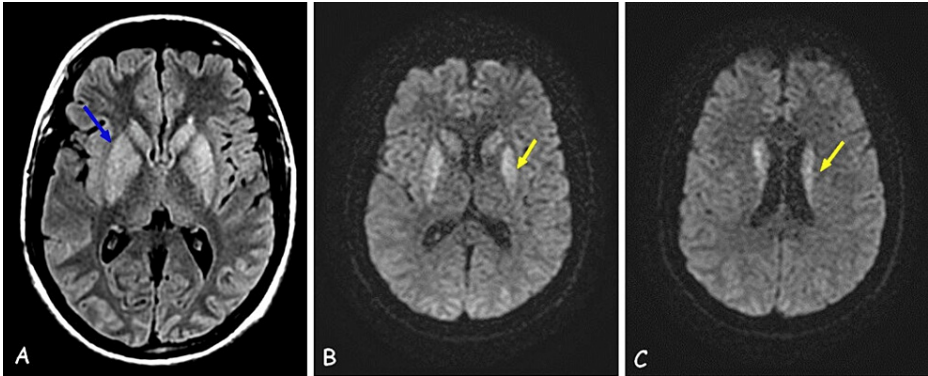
Brain MRI showing bilateral and symmetrical T2 and FLAIR (A) hyperintensity of the basal ganglia with diffusion restriction (B and C).
